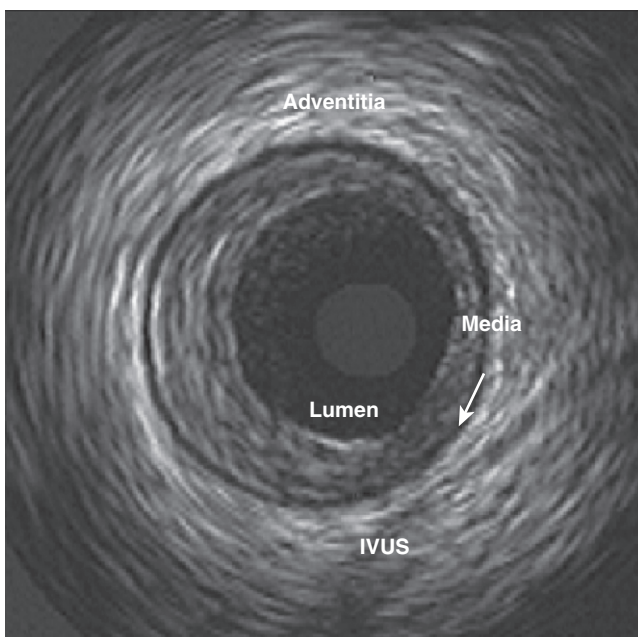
Normal intravascular ultrasound (IVUS) image, demonstrating the three normal layers of the coronary artery—the adventitia is the outermost, separated by a dark echolucent line between the media and the lumen. This an abnormal artery with eccentric plaque from 4 o'clock to 11 o'clock.
